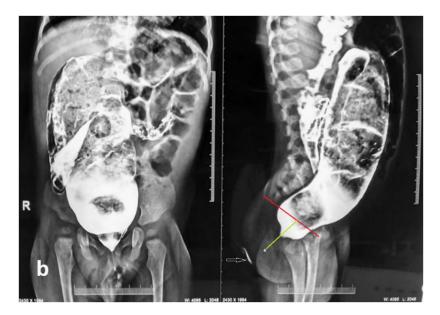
Figure b. "Delayed presentation of a patient of perineal fistula. Watersoluble contrast enema of the same patient showing gross colonic dilation" (caption from article). Judging by the development of the pelvis and joints, this boy is about three years old. On the lateral radiograph, the arrow shows the artifact, which is located outside the buttocks. With a blue dot, I marked the approximate location of the anal fossa, which is located 2.8 cm from the pubococcygeal line (red line). The normal anal canal is located between the anal fossa and the pubococcygeal line (green line). However, the upper half of the anal canal does not work to the feces retention, as the pelvic floor muscles, including the puborectalis muscle, are stretched and weakened by wide fecal masses, which the contracting rectum pushes and cannot push through. Thus, this patient developed megarectum, and descending perineum syndrome. Therefore, despite a well-performed cutback procedure, this patient will have chronic constipation and encopresis.
